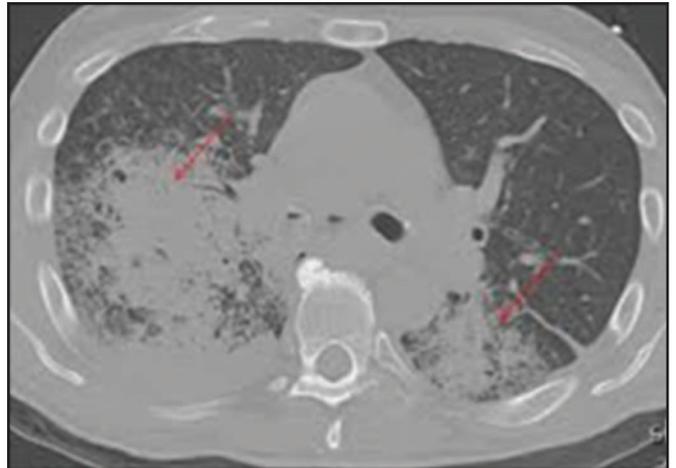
Axial computed tomography image with lung window shows wide bilateral parenchymal consolidations, involving mainly lower lobes.
